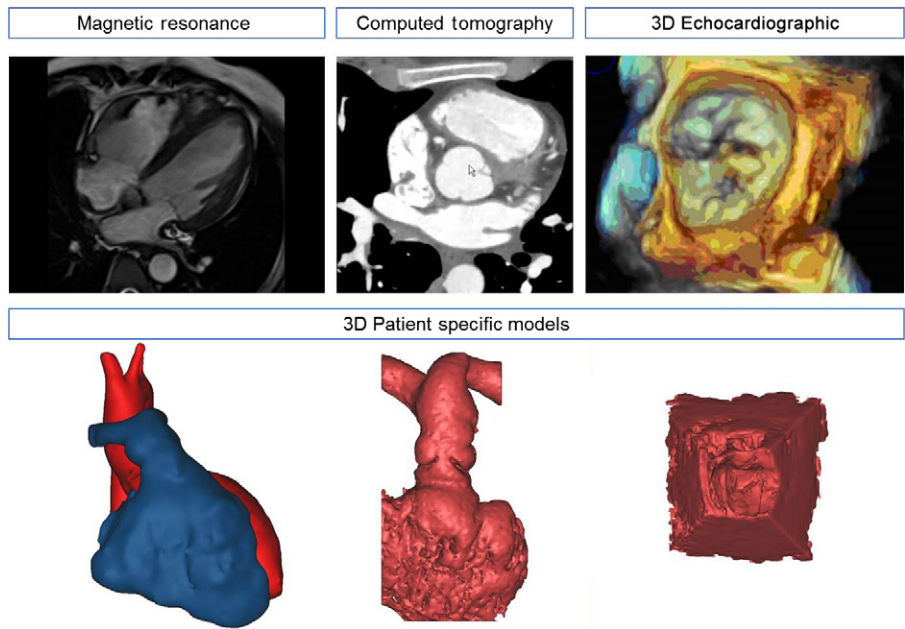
3D models obtained from different imaging modalities: magnetic resonance, computed tomography and echocardiography.
